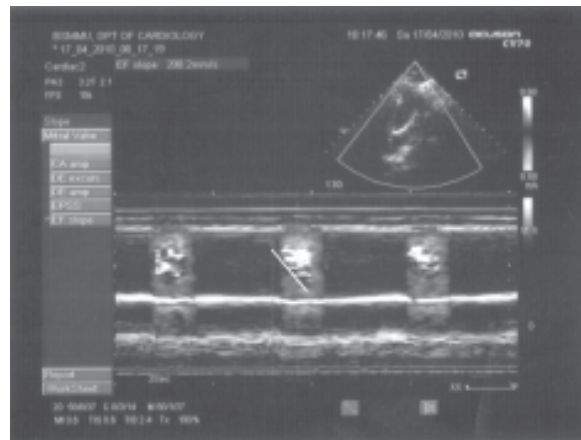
Color M-Mode Doppler Echo shows AVP 20.0 cm/sec.
